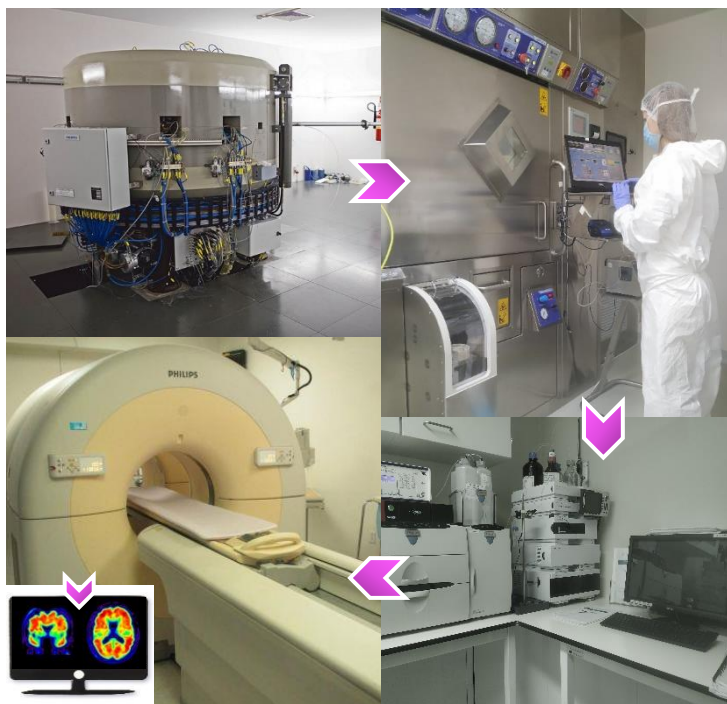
From molecule to man: the process of a PET radiotracer production begins in the cyclotron and ends at the PET/CT scanner, with the patient. From top left: a commercially available cyclotron; an automated radiosynthesis system controlled from outside the hot cell; QC laboratory; a combined PET/CT scanner; a processed PET image.
